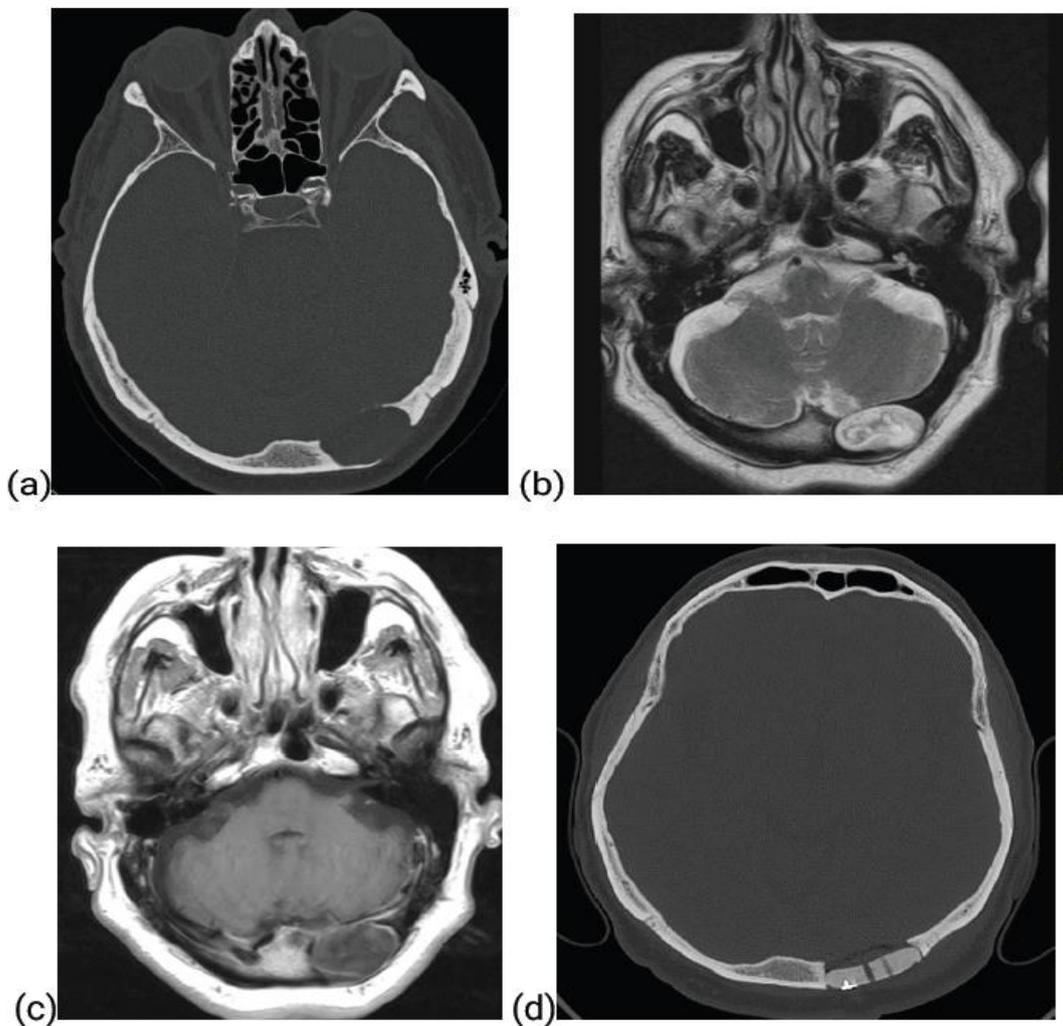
Epidermoid cyst. (a) preoperative CT-bone window with left occipital oval expansile osteolytic lesion. (b) T2WI-MRI shows rounded circumscribed extracranial hyperintense soft-tissue mass. (c) T1WI-MRI post-contrast demonstrates the lesion with its capsule. (d) postoperative bone window after 3D reconstruction of the skull.
